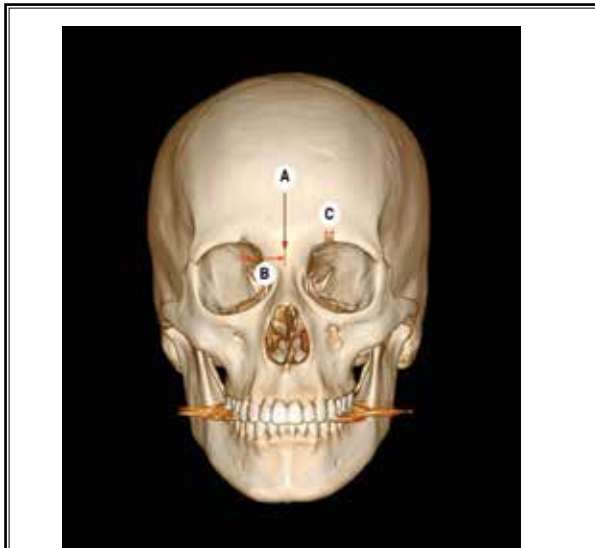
Facial bone 3D CT image showing measurement of parameters. (A) Red arrow indicates nasion (midpoint). (B) Distance from the center of supraorbital notch or foramen to the nasion. (C) Measurement of diameter of supraorbital notch or foramen.
